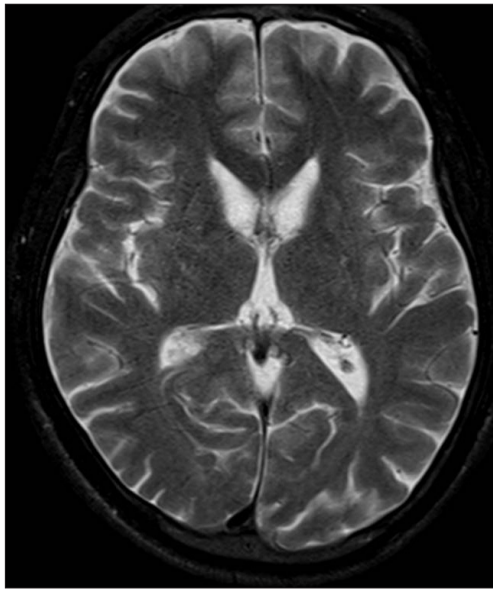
T2-weighted MR imaging showed mild bilateral atrophy of the head of the caudate nucleus.
